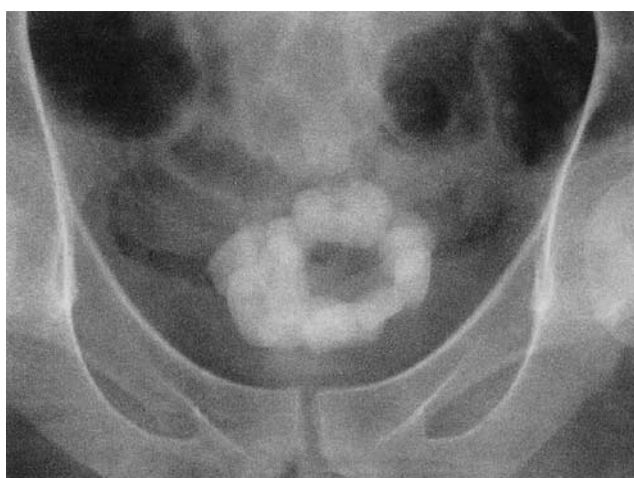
X-ray of abdomen, taken on 28 September 2001, shows a faintly radio opaque calculus projected over the bladder
